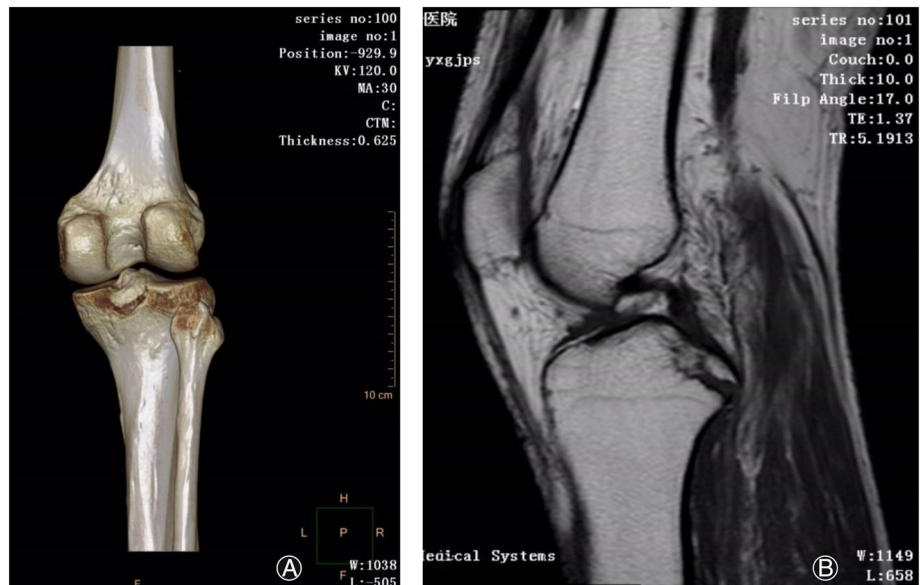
Evaluation of the displacement and configuration of an avulsion fracture fragment of the posterior cruciate ligament tibial attachment by MRI (A) and CT (B). CT showed the tibial intercondylar eminence fracture. MRI showed the tibial intercondylar eminence fracture of PCL insertion
